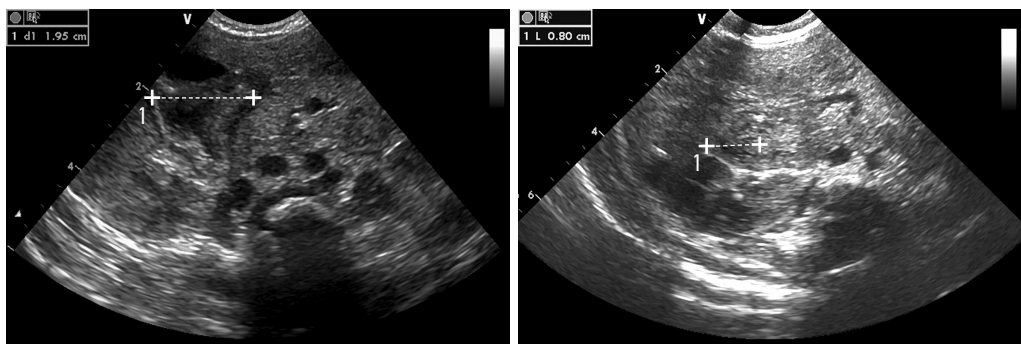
Example of duodenal dilatation in a newborn on ultrasound, B-mode (left). Second segment of the duodenum in a healthy newborn (right)
